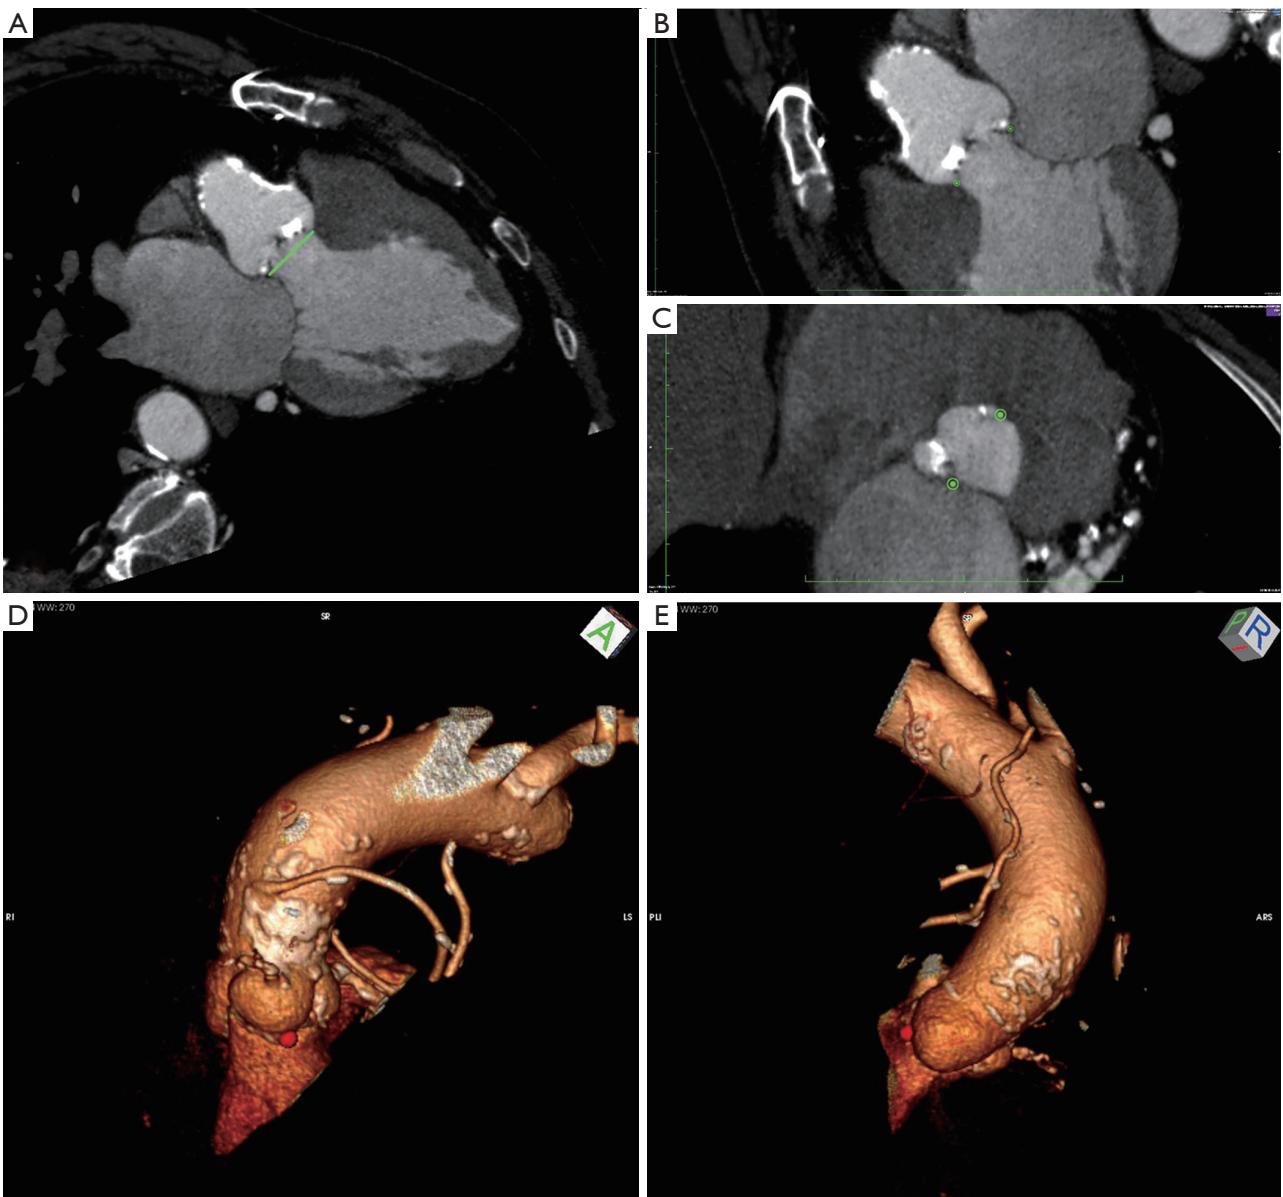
Bi-dimensional imaging is limited in its ability/capacity to measure the “true” annulus diameter. A. In this example, the annulus has been measured as the hinge-to-hinge distance between two cusps (non-coronary and right coronary) on the the 3-Chamber view at MDCT, a multiplanar reconstruction that closely approximates the mid-esophageal long axis view at the TEE (see *Figure 3*); B. The hinge point of the two cusps has been marked by selecting two regions of interest (ROI's, green mark) on the CT image; C. Axial oblique reconstruction showing the position of the two ROI's as they were set in the previous step. Note that while the ROI at the hinge point of the right coronary cusp its close to the correct position, the ROI on the non-coronary sinus is well away from the true hinge point of the corresponding aortic cusp. Also note that this plane does not correspond to the true virtual basal ring plane (see *Figure 4*) and measurements made on this image would probably be inaccurate. In this example, the measurement (24.1 mm) is close to the minimum diameter and 3 mm smaller than the average diameter calculated from the area of the true basal ring (see *Figures 4, 5*). D, E. three-dimensional reconstructions demonstrating again the near correct position of the ROI (red dot) at the hinge point of the right coronary cusp and the wrong position of the ROI on the insertion of the non-coronary cusp
